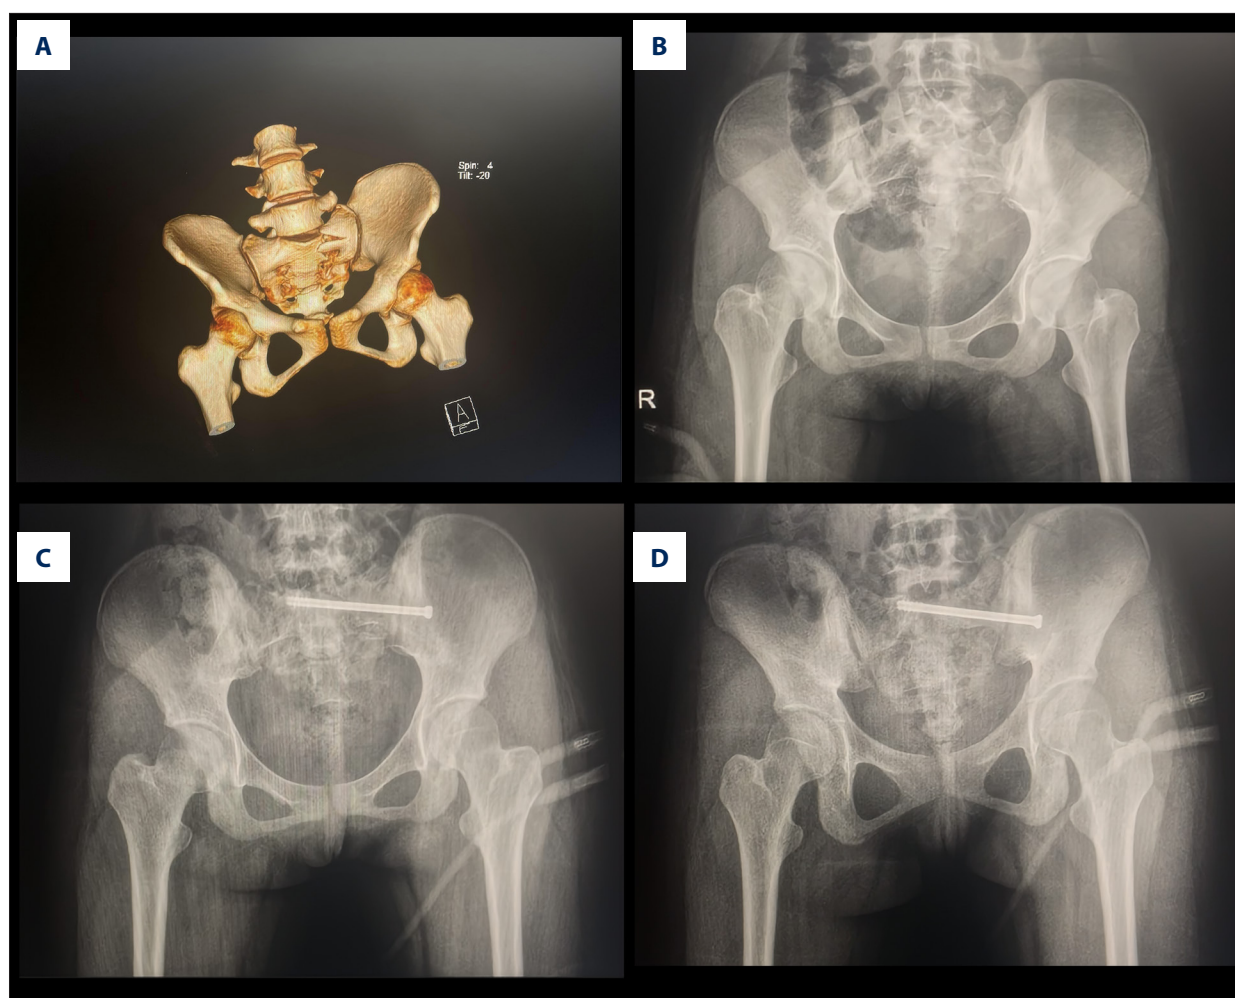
Percutaneous posterior closed screw internal fixation for a female patient with Tile B pelvic fractures. (A) Preoperative 3-dimensional reconstruction of pelvis. (B) Preoperative pelvic anteroposterior X-ray. (C) Postoperative pelvic anteroposterior X-ray. (D) Postoperative pelvic inlet X-ray. Figure created by WPS picture (windows 12.1.0.19302, Kingsoft Office).
